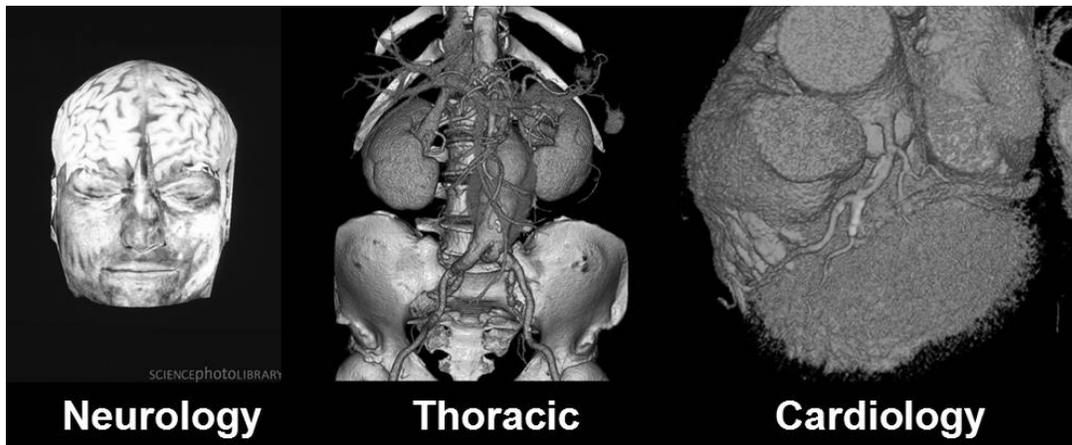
Contemporary Medical CT Images indicating current capabilities
